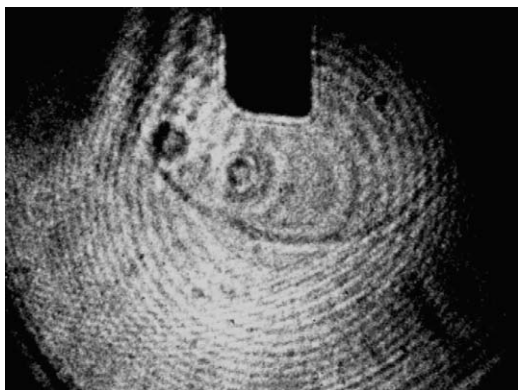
Ultrasonic tip in water bath showing wave propagation and presence of presumed cavitation bubbles.
